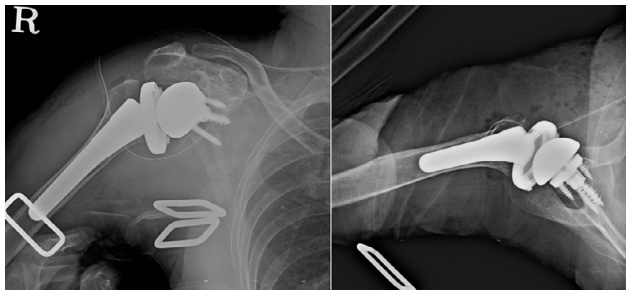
X-ray after reverse total shoulder arthroplasty.
